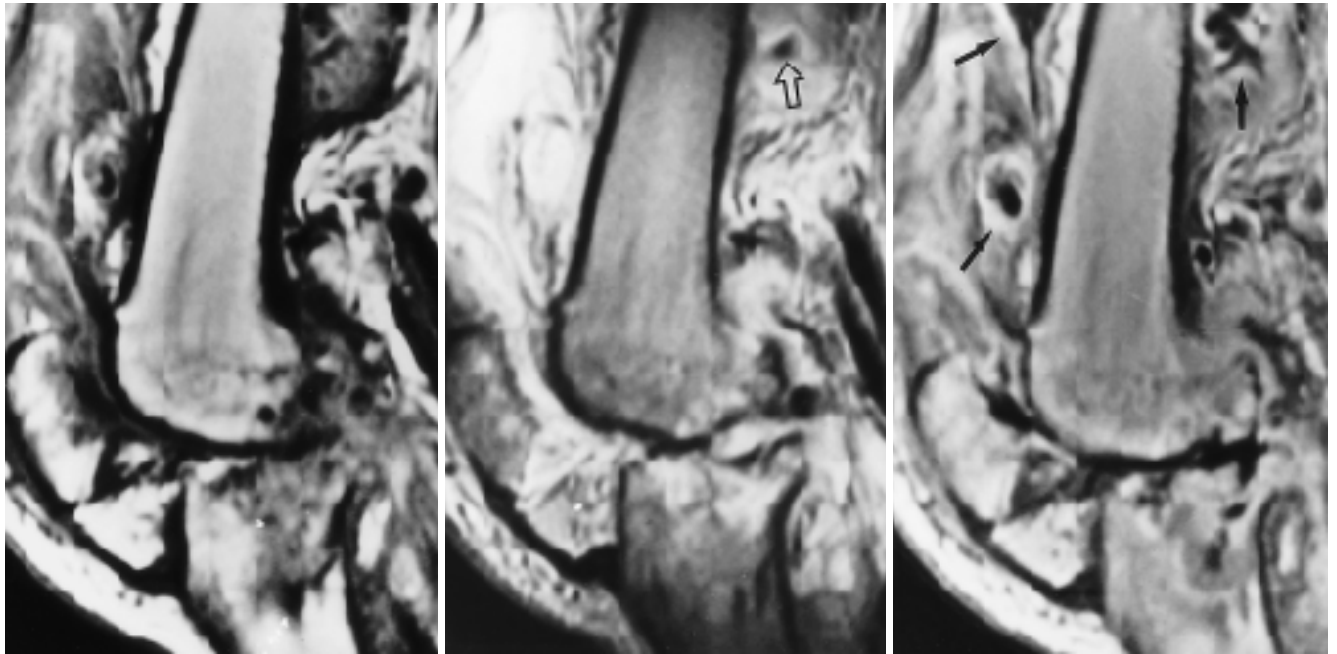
Tuberculous arthritis in a 53-year-old female. Sagittal T1-weighted image(A), sagittal T2-weighted image(B) and sagittal enhanced T1-weighted image(C) show extensive intermuscular and intramuscular paraarticular abscess formation(arrows) and soft tissue edema around the knee. A portion of abscess shows low signal intensity on T2-weighted image(open arrow). Multiple large bone erosions with bone marrow edema are noted in the tibial condyle.
